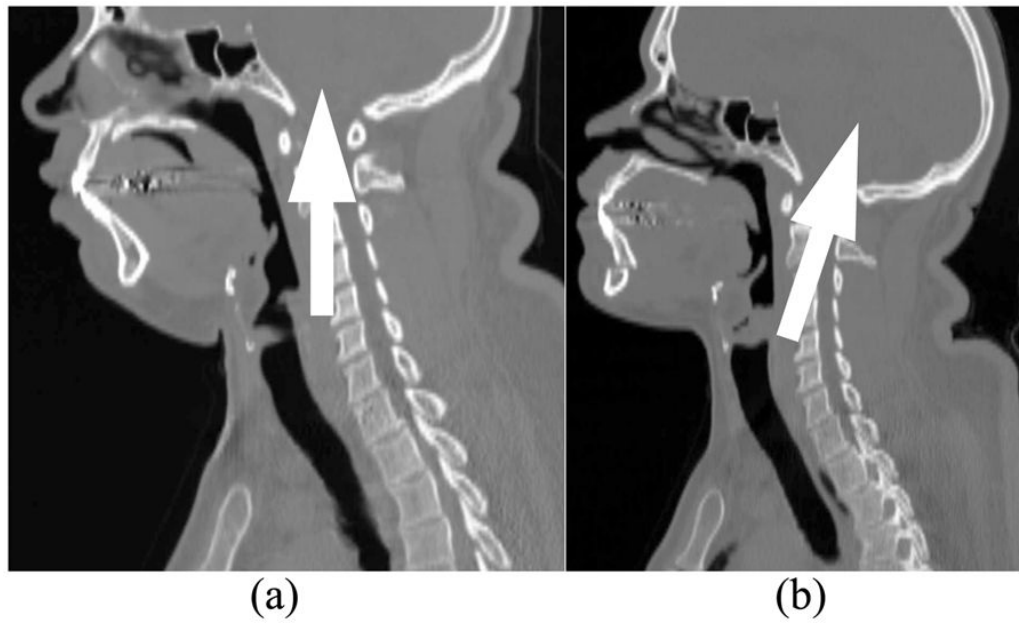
Side view of Case 7 CT data sets with arrows indicating head direction: (a) Preoperative; (b) Postoperative
